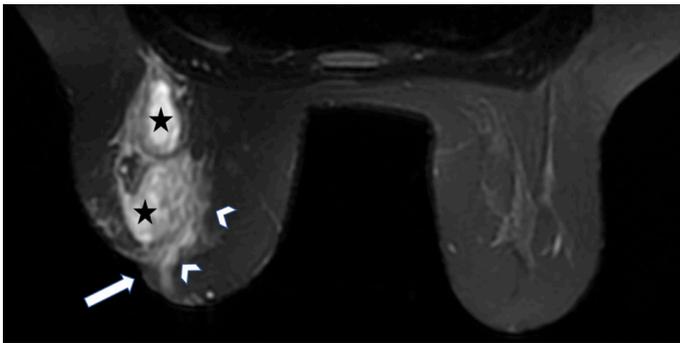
A 40-year-old patient with GM in the right breast. Axial T2-weighted MRI shows nipple retraction (arrow) hyperintense lesions consistent with fluid collections (stars) and parenchymal edema (arrowheads). There is no finding in the right breast.
